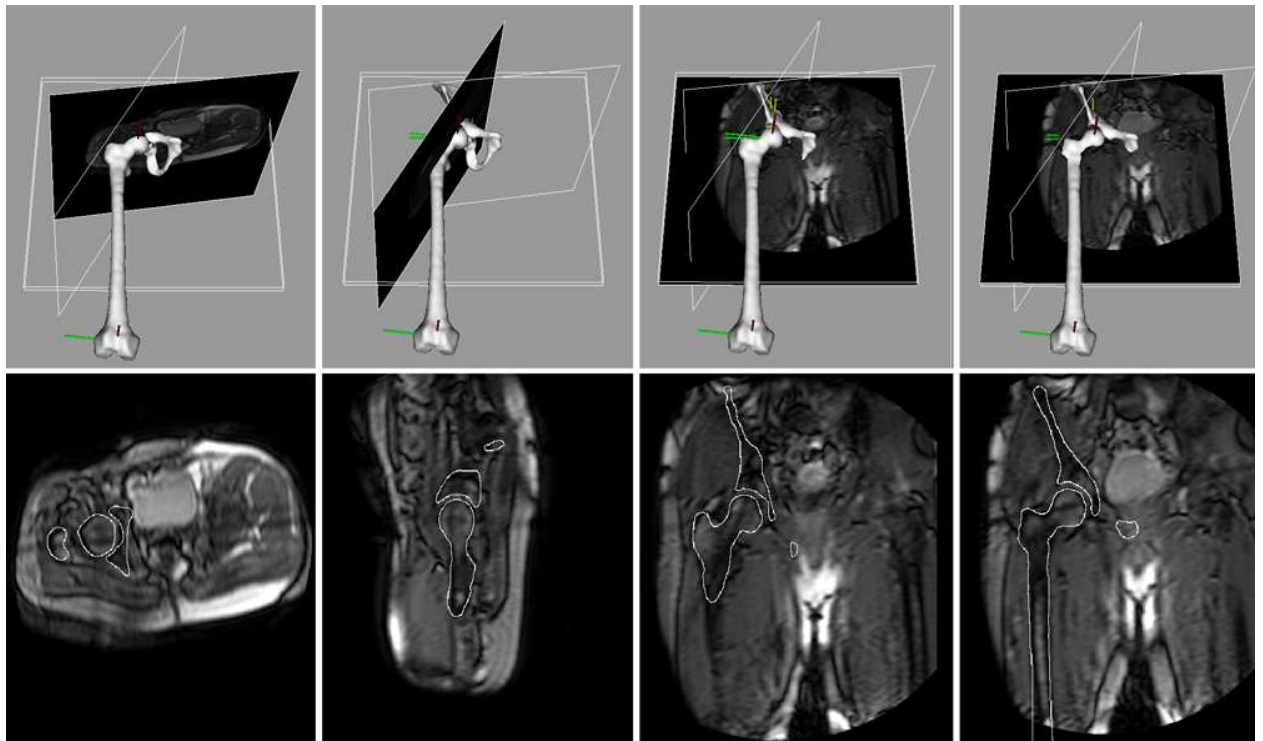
Bone tracking results in real-time dynamic MRI, at a sample frame
